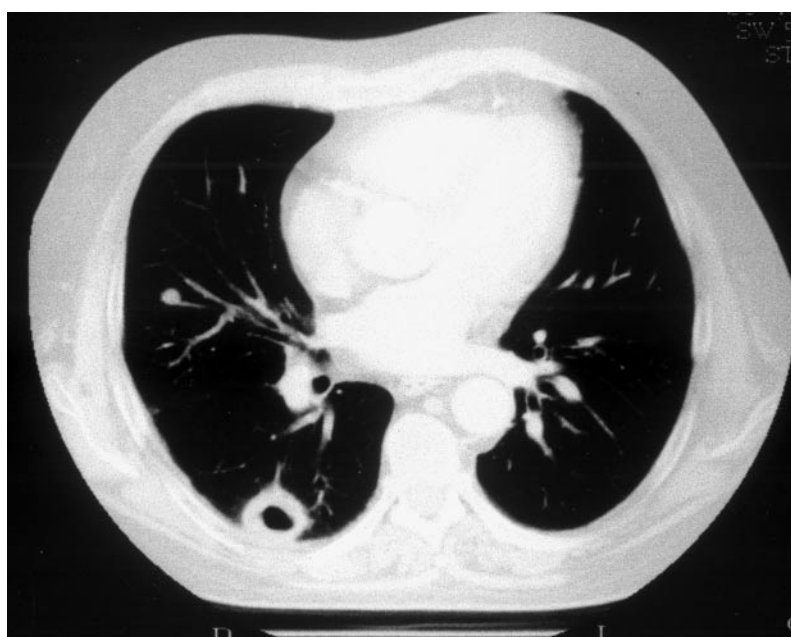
Thoracic CT scan in "lung window" showing a nodular lesion in middle lobe of the lung and a cavitary lesion in the lower lobe.
